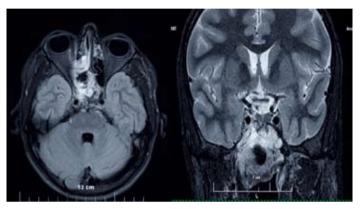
Follow up MRI one year post treatment
